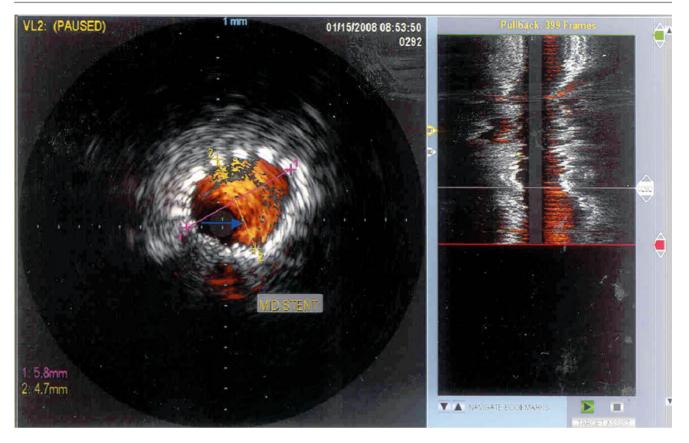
Intravascular ultrasound (IVUS) image of a stent deployed in the internal carotid artery. Pullback of IVUS catheter identified mild stent deformation compared to distal and proximal stented segments. Color flow indicates widely patent stent without lumen debris
